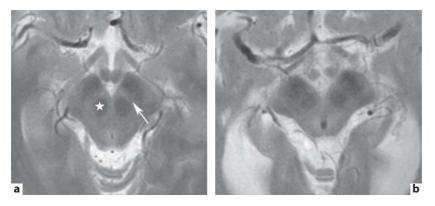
Three Tesla T2-weighted magnetic resonance images in the axial plane at the level of the red nucleus (star) and substantia nigra (arrow on the pars compacta) in a normal subject (a) and in a PD patient with dementia (b) showing the global atrophy of the mesencephalon and the severe atrophy of the pars compacta of the substantia nigra.
